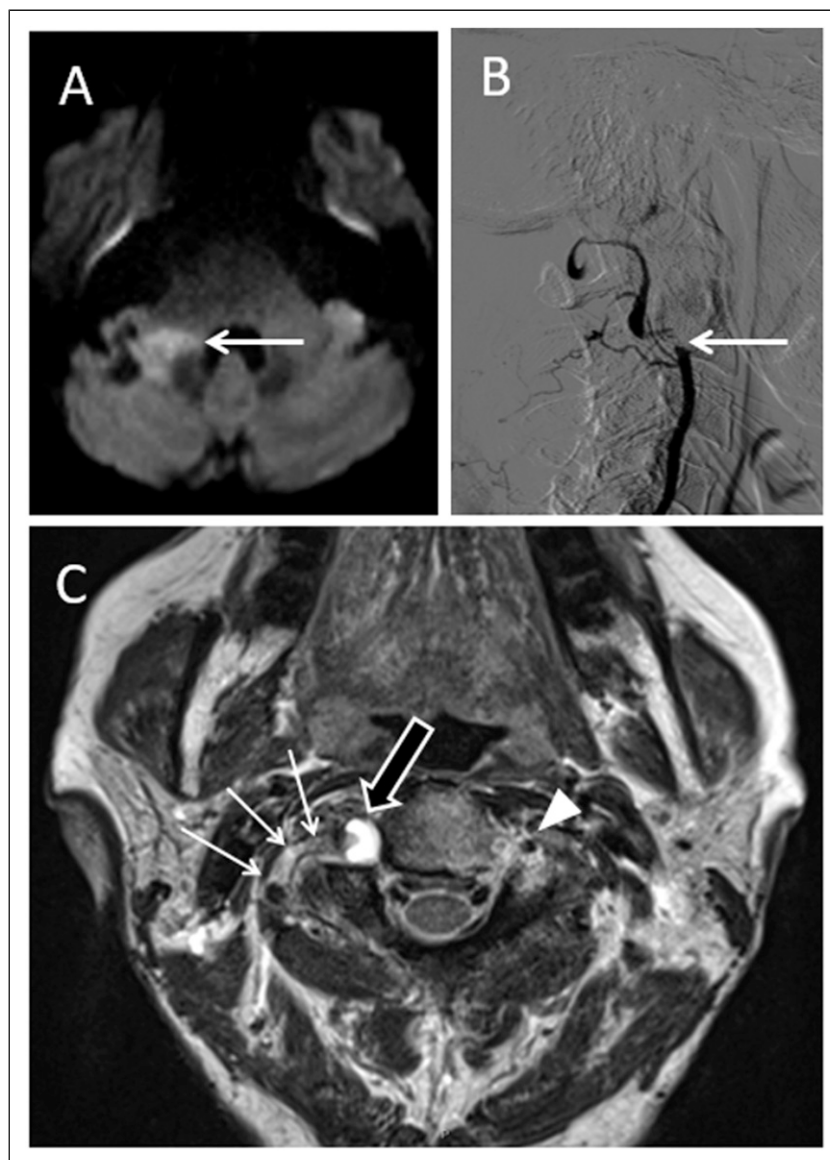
Case no. 4. (A) DWI-MRI showing a subacute right middle cerebellar peduncle stroke. (B) Digital subtraction angiography with V3 subocclusion. (C) T2-weighted MRI with C2 vertebral body liquid-filled ganglion cyst (black arrow), thrombus in adjacent right vertebral artery (white arrows), and flow void in the normal left vertebral artery (white arrowhead).
